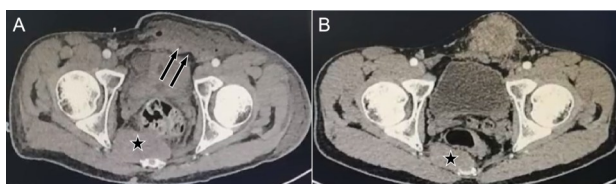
Postoperative CT examination (A) showed that there was no obvious tumor recurrence at the operation site of the left groin area (arrows), but the soft tissue mass in the coccyx area was larger than before operation (pentagram arrow, B is preoperative).
